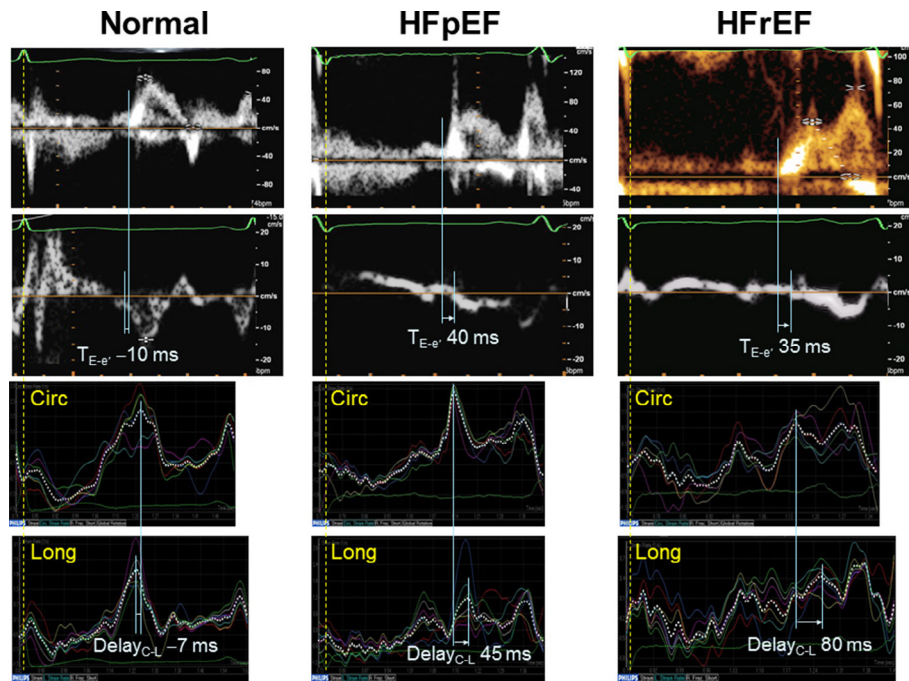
Mitral Doppler inflow, mitral annular velocity, and strain rate curves obtained from a normal subject, a patient with heart failure with preserved ejection fraction (HFpEF), and a patient with heart failure with reduced ejection fraction (HFrEF). In the normal subject, a simultaneous occurrence is observed in the early diastolic mitral inflow and mitral annular velocity as well as in the circumferential SR_E and longitudinal SR_E . In contrast, a prolongation of $T_{E-e'}$ as well as Delay_{C-L} was observed in the patients with HFpEF and HFrEF. Circ, circumferential; Long, longitudinal; other abbreviations are the same as Fig. 1.
